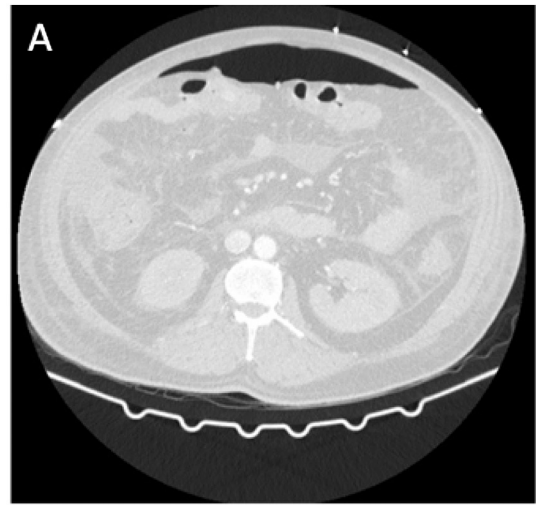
Abdominal CT in axial (A) and sagittal (B) sections showing pneumoperitoneum and free fluid in the abdominal cavity.
